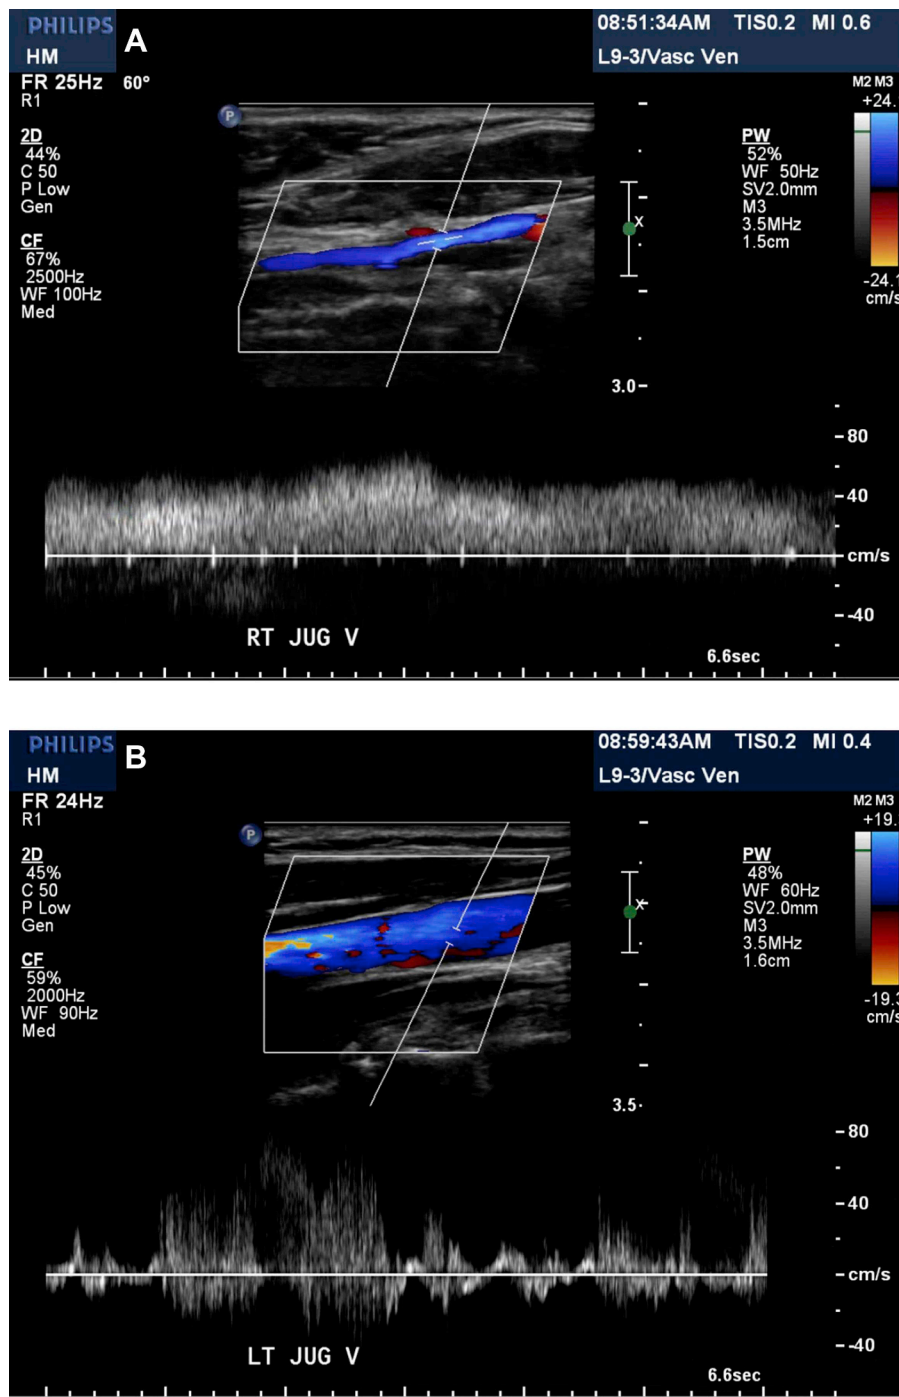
Neck Ultrasound A. Right internal jugular vein with normal flow. B. Left internal jugular vein with normal flow.
